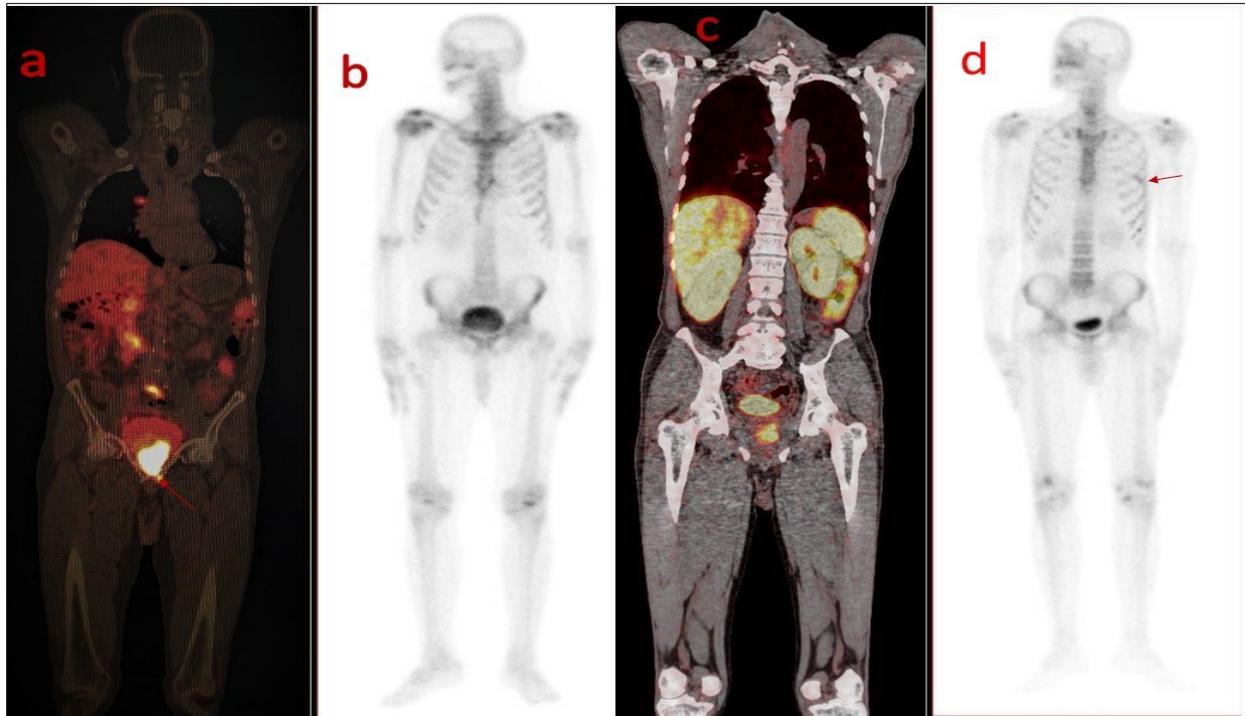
Bone lesion on PSMA-PET/CT & Bone Scan
